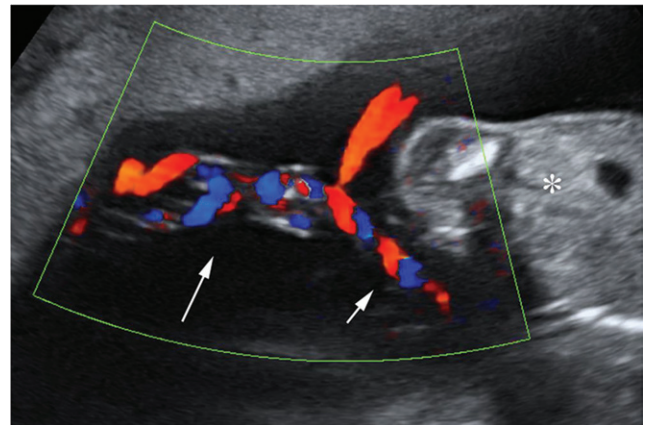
Ultrasound image of Case 1 at 23 + 2 weeks, showing entanglement of the two cords (long arrow) and a very short length of free parasitic twin umbilical cord at abdominal insertion (short arrow). Asterisk indicates the parasitic twin.
